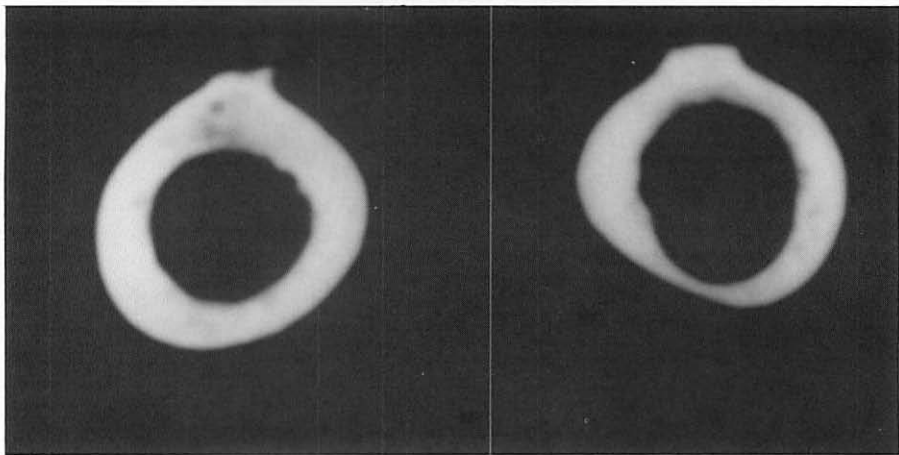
CT scan through the area of the lesion demonstrated in Figure 3.
